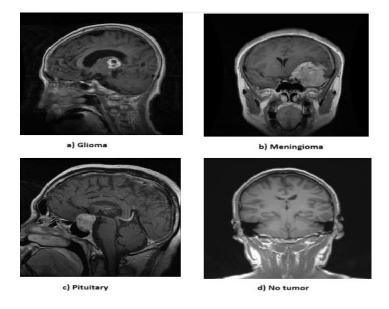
Sample MRI Images from the Dataset
